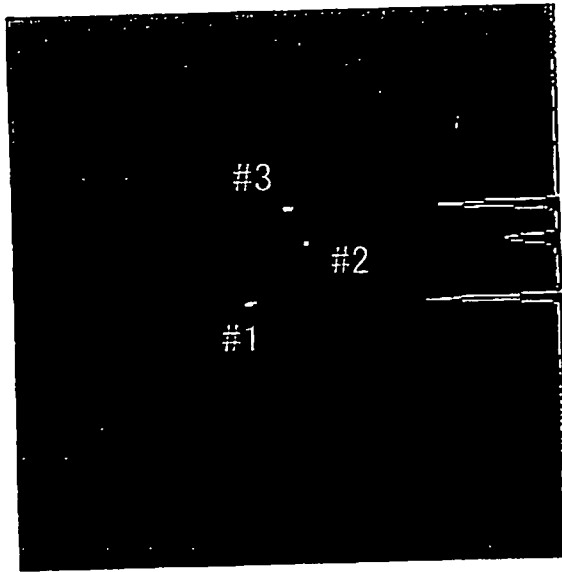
作成したトラッキングコイルによる MRI 画像とプロジェクションデータ
